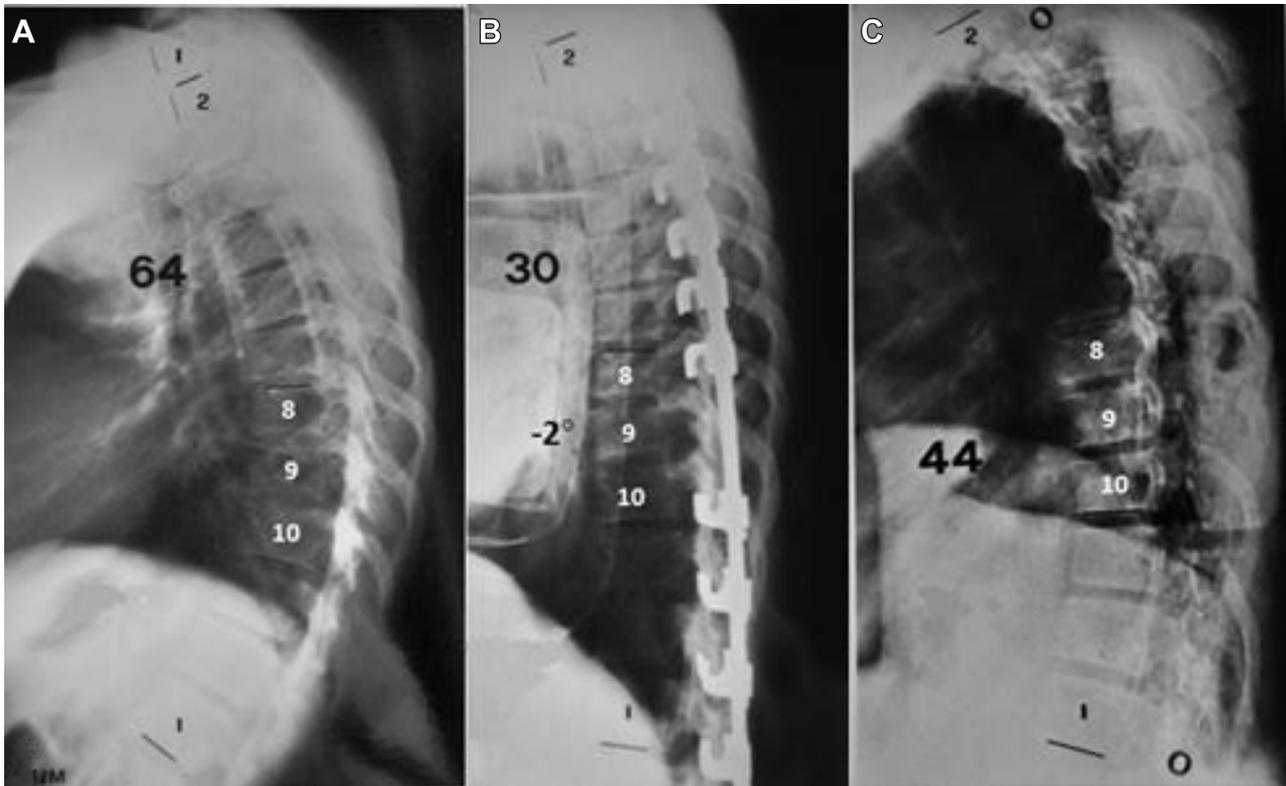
Example of a postoperative neurologic complication on a likely vascular basis. An apical overcorrection with a T8–T10 lordosis of 2 degrees causing a medullary ischemia was the most likely reason inducing a paraparesis at level T8. Complete recovery occurred after immediate implant removal. (A) Standing lateral preoperative radiograph. (B) Postoperative lateral radiograph showing a segmental lordosis at T8–T10. (C) Standing lateral radiograph 8 days after surgery showing the correction in a Risser localizer cast.
